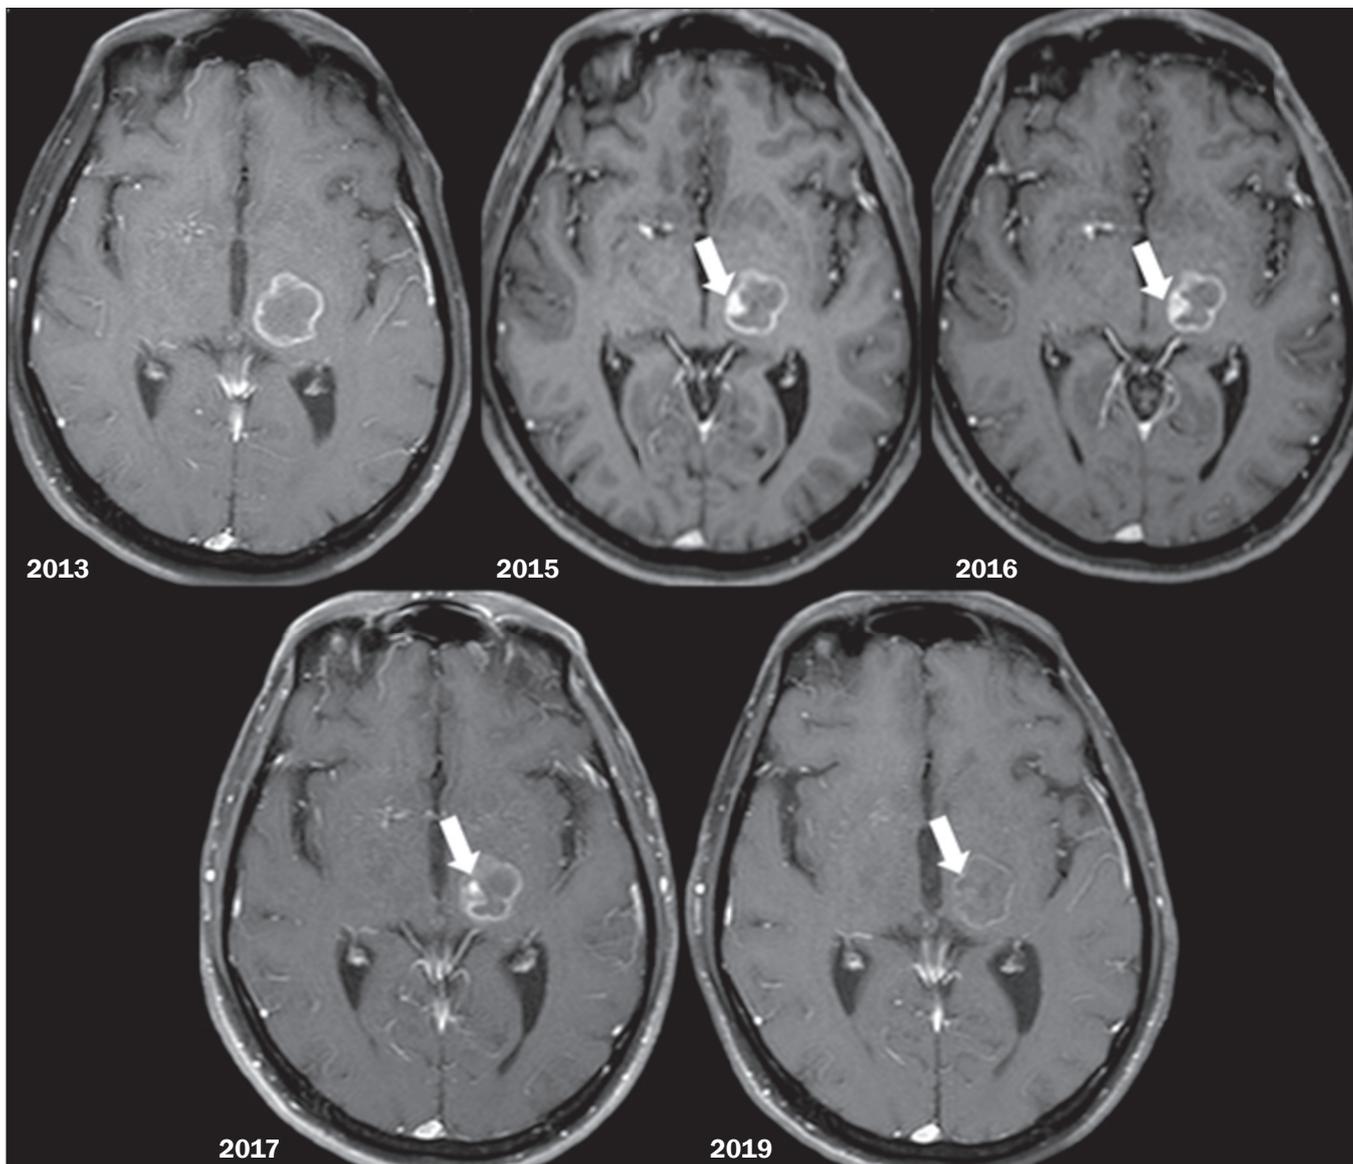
Axial contrast-enhanced T1-weighted images showing the appearance and progressive enlargement of the eccentric nodule ("Star of Bethlehem sign", arrows), followed by a reduction in the size and degree of contrast enhancement of the nodule over time in a left thalamic lesion.
